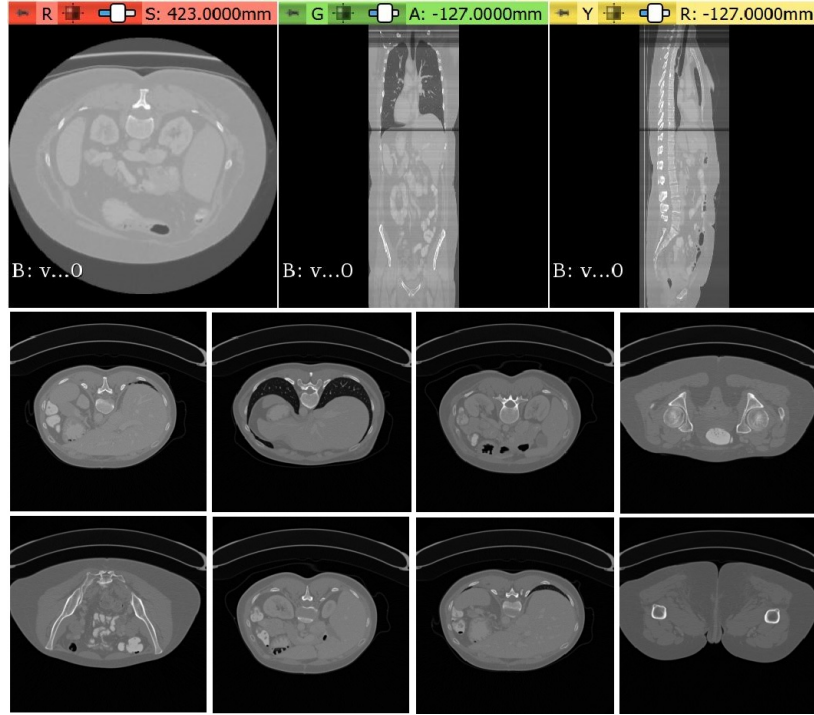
CT scan DICOM: liver segmentation extracted for 3D reconstruction
